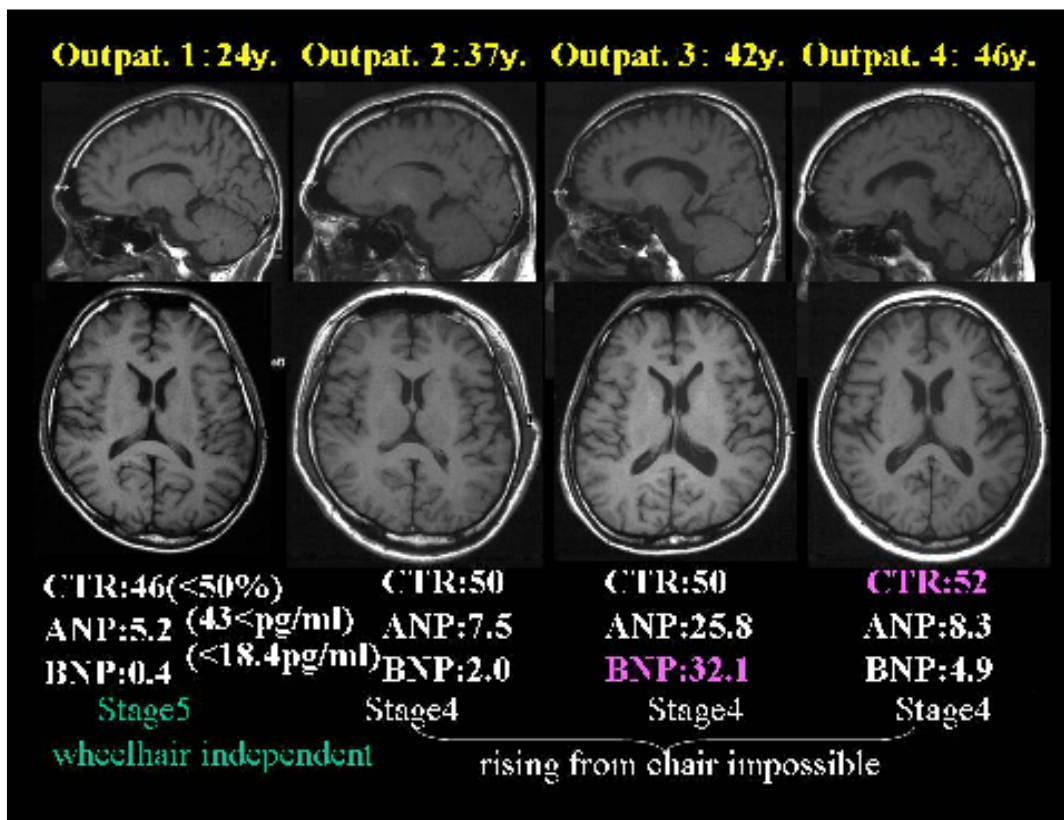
MRI findings. We observed no association between the MRI findings and the muscle function test.
